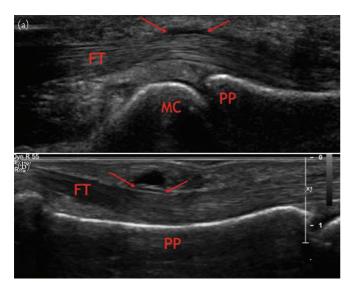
Trigger finger on ultrasound. Grayscale sonographic image (a) of the flexor aspect of the finger in longitudinal plane at the level of the metacarpophalangeal joint (MC = metacarpal head and PP = proximal phalanx). Thickened A1 pulley (between arrows) appears as a linear hypoechoic structure at the level of the metacarpal head (MC) immediately superficial to the flexor tendons (FT). The normal pulley is a thin linear almost imperceptible hypoechoic structure immediately superficial to the flexor tendons. Grayscale longitudinal image (b) of a minimally thickened A2 pulley (between arrows) at the mid-proximal phalanx (PP) level. A small hypoechoic structure is associated with this A2 pulley. This is a simple cyst.
